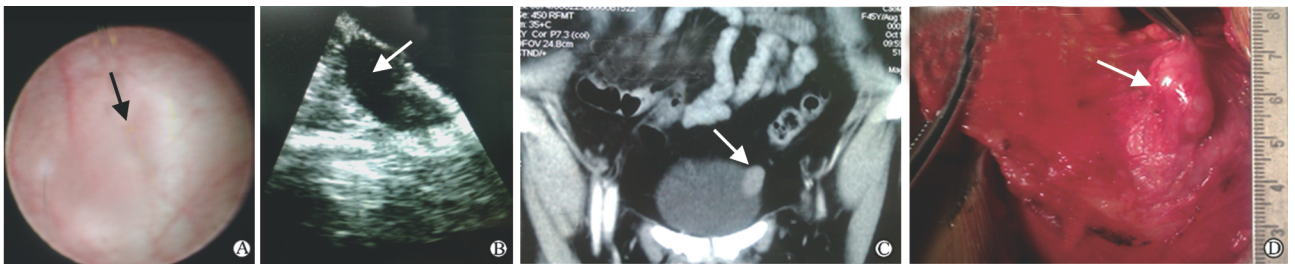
膀胱肌层平滑肌瘤超声内镜、增强 CT 及术中表现
